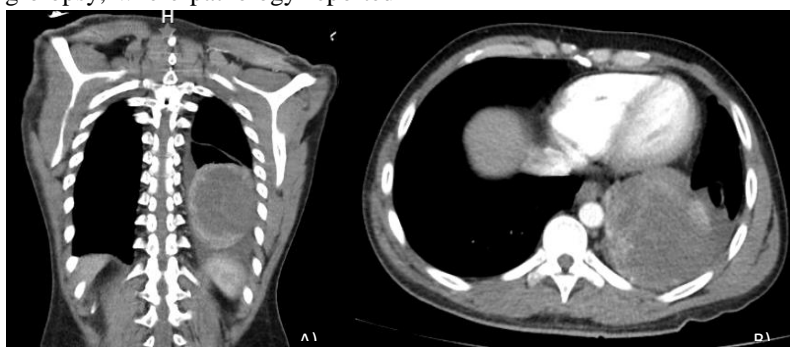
Thorax and abdomen CT with IV contrast 04/09/23: irregular mass in the left inferior lobe, irregular borders, with heterogeneous reinforcement after IV contrast. 9.4 cmx8.3 cm axial cut. Left bronchial with obstruction, and small pleural effusion. Mediastinal enlarged lymph nodes. A) Coronal View, chest sequence. B) Axial View, chest sequence.
